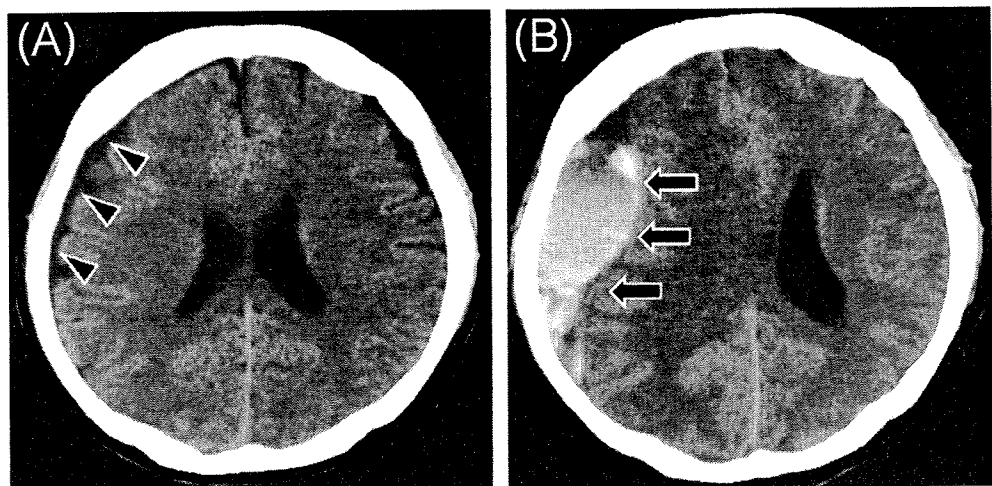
A: Axial computed tomographic scan of the head indicating chronic SDH shown as iso-density area in the right temporal lobe on October 3 (arrowheads), B: acute SDH shown as high-density area in the right temporal lobe on November 13 (arrows).
